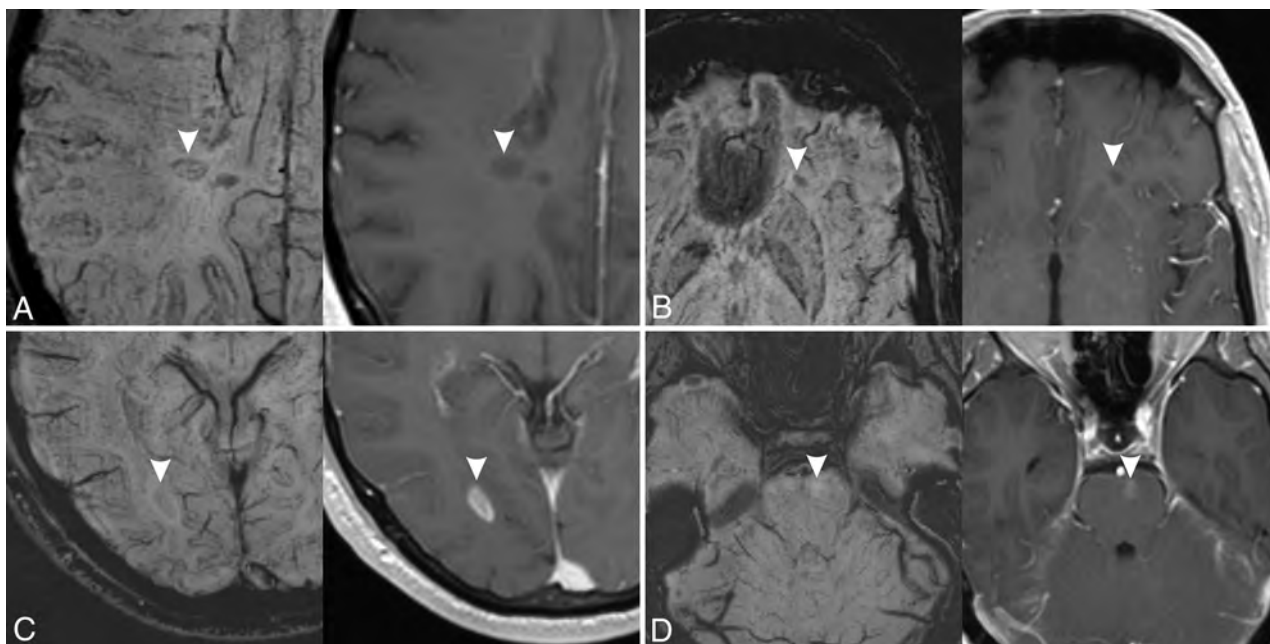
Examples of MS lesions (arrowheads) with different signal patterns on SWI (left) and corresponding contrast-enhanced T1-weighted images (right). A, Hypointense ring. B, Marked hypointensity (dot-shaped). C, Mild hypointensity. D, Iso-/hyperintensity. Lesions in A and B do not show enhancement on postcontrast images, while lesions on C and D show enhancement on postcontrast images.
